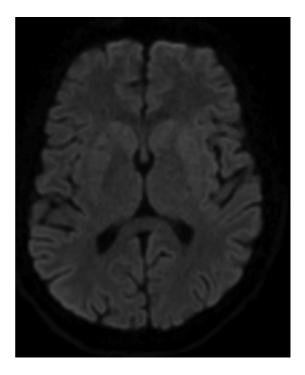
Axial Brain MRI with no DWI hyperintensity.
